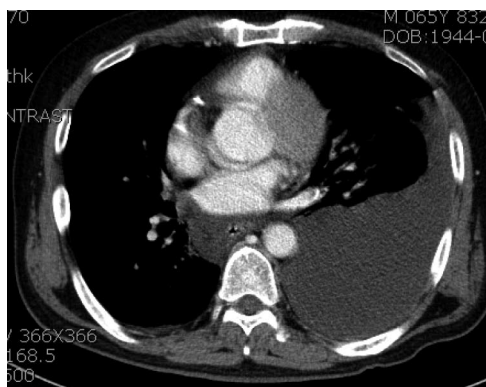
Chest computed tomography shows a left pleural effusion and peri-esophageal fluid collection.
